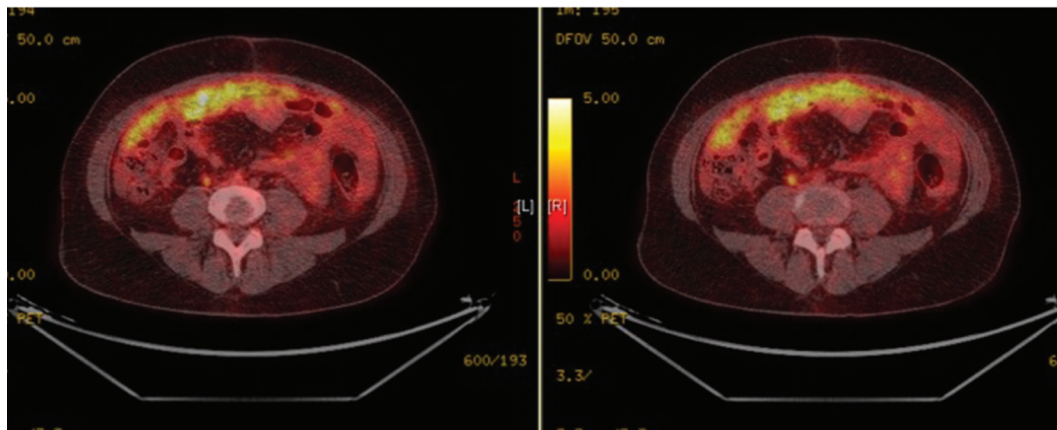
Diagnostic PET-CT previous to treatment in case 3. Omental cake.
